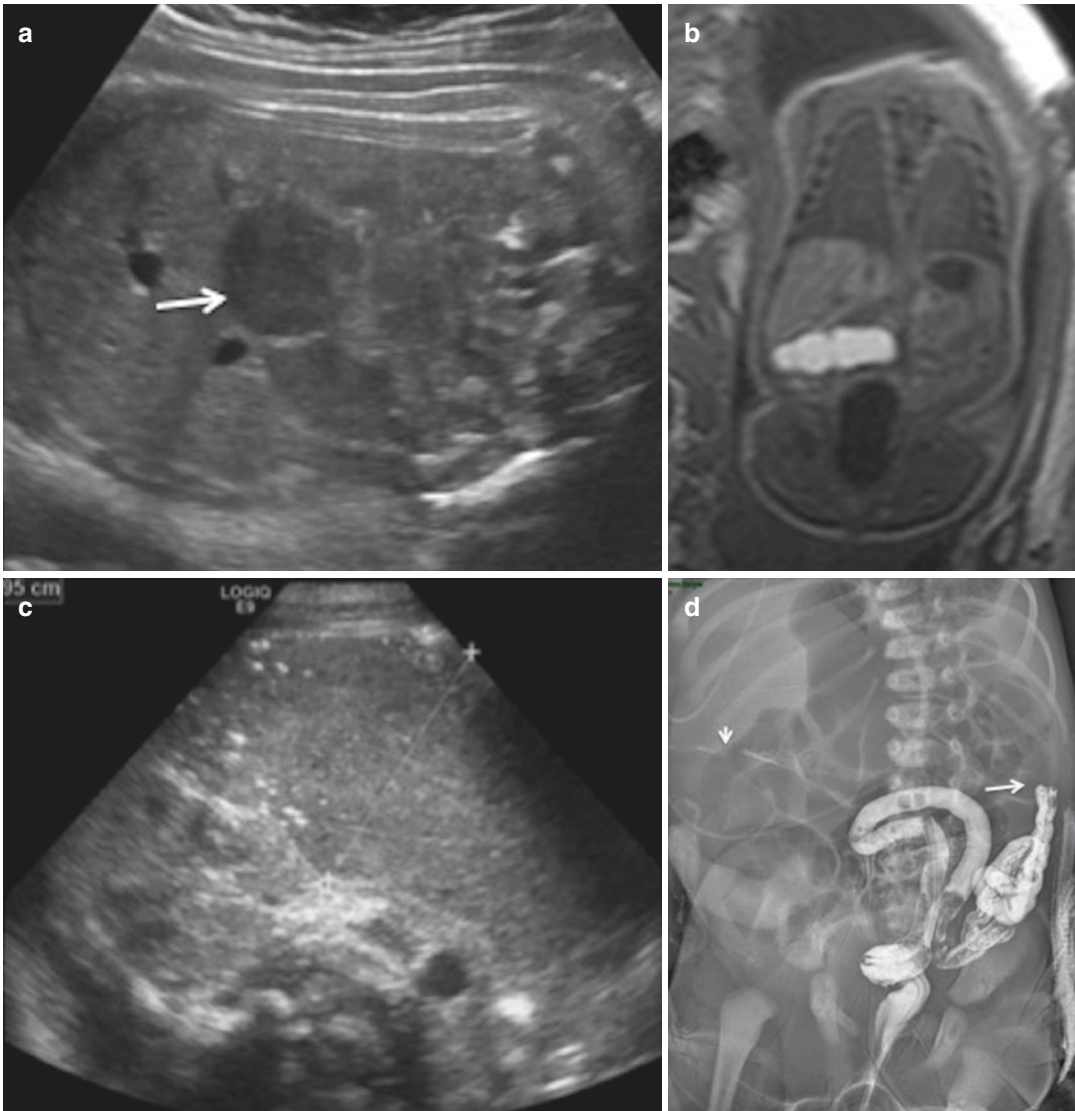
Colonic atresia (Courtesy A. Massez MD). (a) Axial US scan of the abdomen of a 35-week-old fetus presenting a distended digestive loop with echogenic content (*arrow*). The differential diagnosis between dilated small bowel and colon is difficult. (b) MR imaging: coronal T1 weighted sequence shows that the dilated hyperintense loop corresponds to the colon filled with meconium. Only
